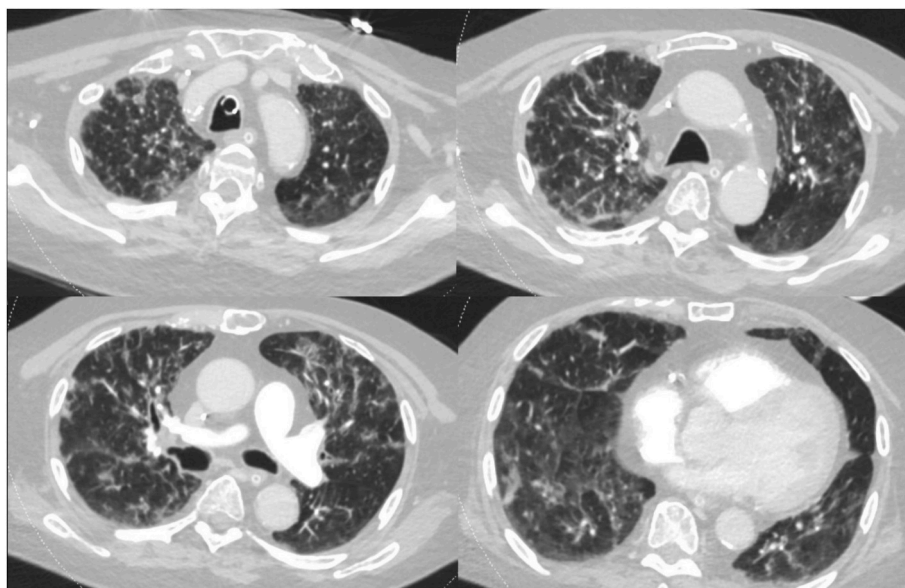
Chest computed tomography revealed diffuse interstitial mixed with multifocal irregular consolidation infiltrates.
